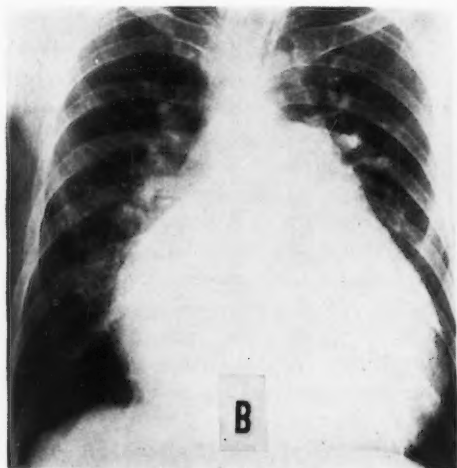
B. Roentgenogram of chest in same patient 5A showing extreme cardiac enlargement and pulmonary vascular engorgement. C. Angiocardiogram showing anomalous vein entering left innominate vein filled by reflux of contrast material into anomalous vessel.
